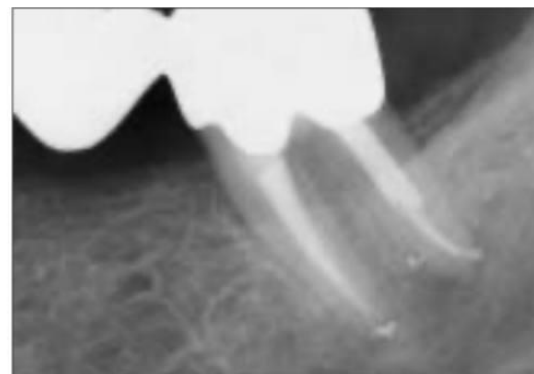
a. A pre-operative radiograph of an endodontically involved mandibular left second molar bridge abutment. Note the previous access and possible floor perforation.
